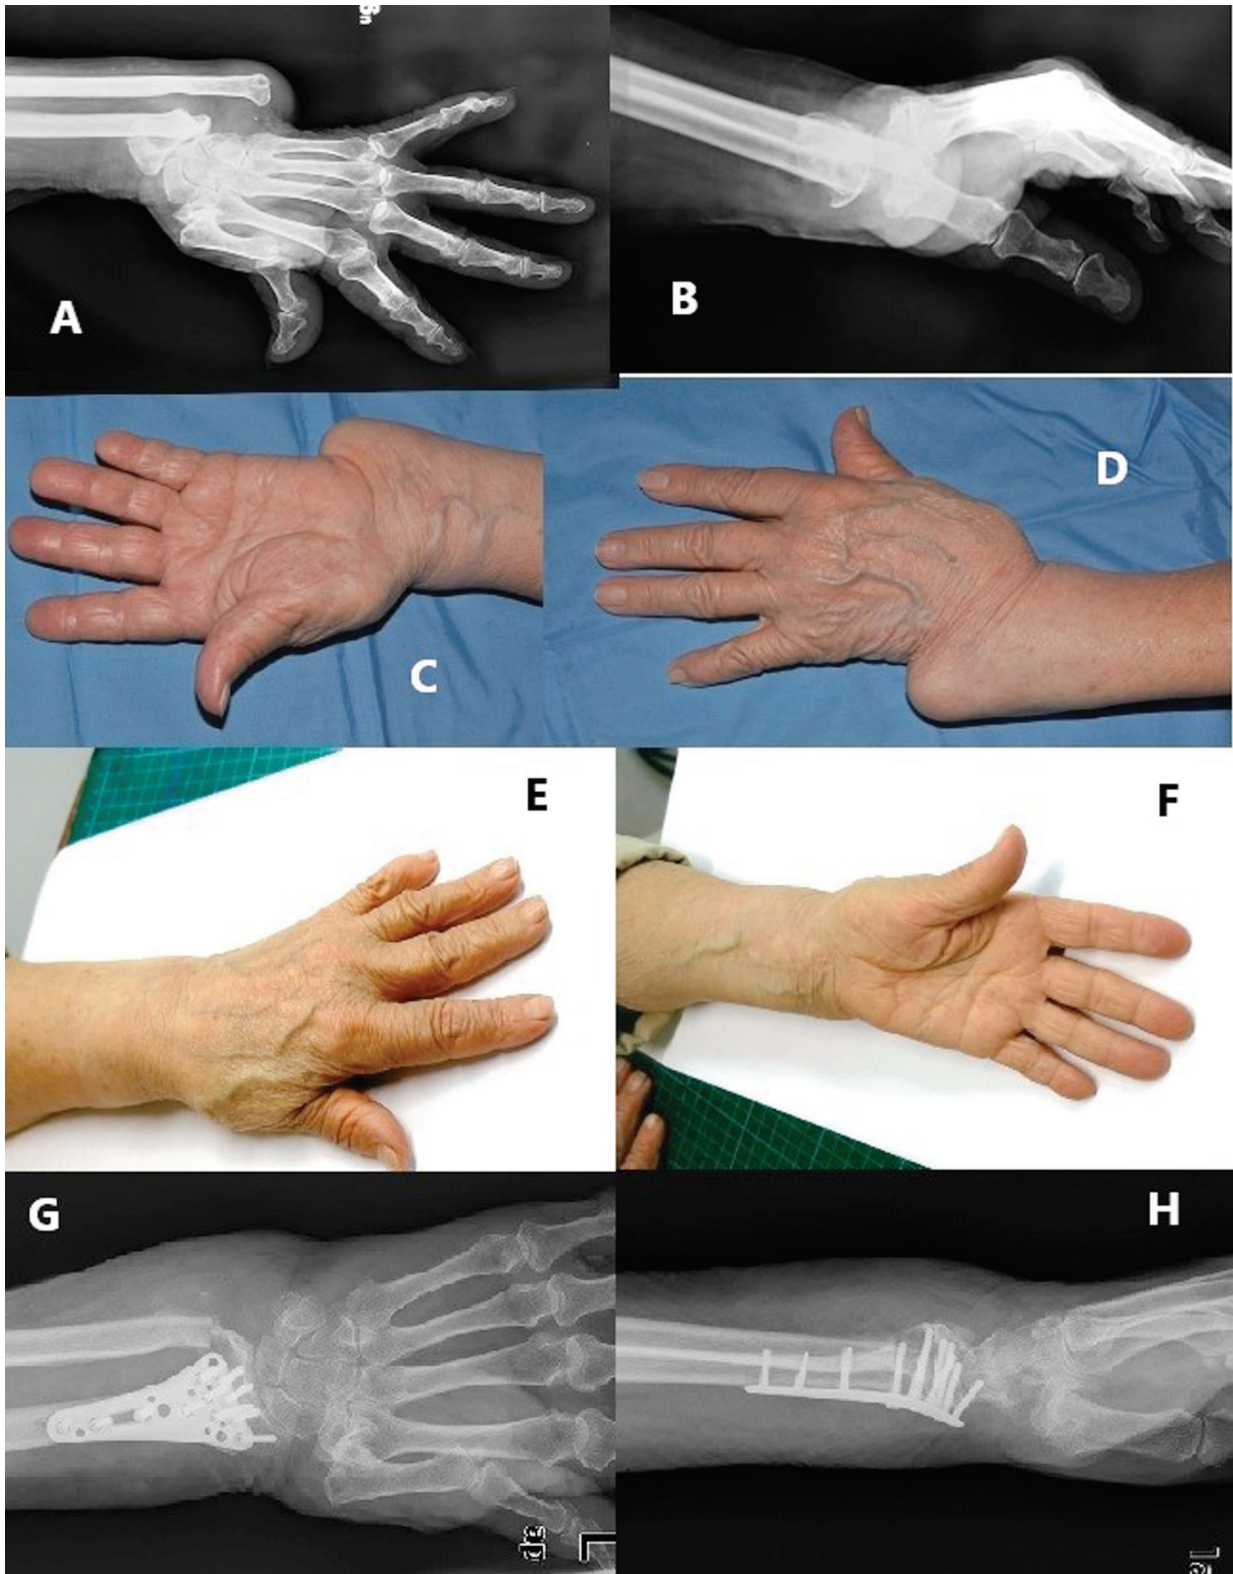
(Case 2): A,B,C,D) Severe wrist deformity with radial deviation and plus of the ulna; A) A/P X-ray; B) L/L X-ray; C) clinical palmar view; D) dorsal view. E,F,G,H) Result 6 months after corrective surgery with Darrach procedure and distal radius addition corrective osteotomy; E) clinical dorsal view; F) palmar view; G) A/P X-ray with plate; H) L/L X-ray with plate
